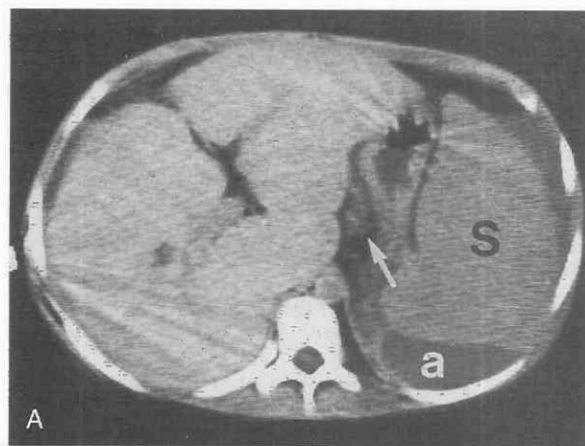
Autosomal recessive polycystic kidney disease in a 14-year-old girl with normal renal function. *A*, The liver contour is irregular as a result of congenital hepatic fibrosis. The spleen (S) is enlarged because of portal hypertension. Ascites (a) is present, and there is an enlarged left gastric vein (arrow) in the hepatogastric ligament. *B*, A more caudal scan shows mild nephromegaly and multiple medullary cysts with relative preservation of the renal cortex. (From Levine E: Computed tomography of renal masses. Crit Rev Diagn Imaging 24:91-200, 1985.)
